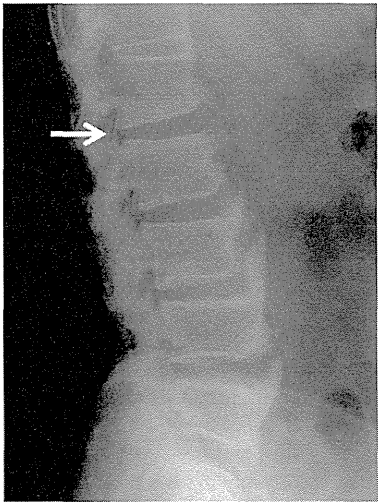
A lumbar spine radiograph at the age of 50 years. Note anterior osteophytes with a coarse trabecular pattern from L3 to L5 regions. The arrow denotes ossification of the posterior longitudinal ligament.
